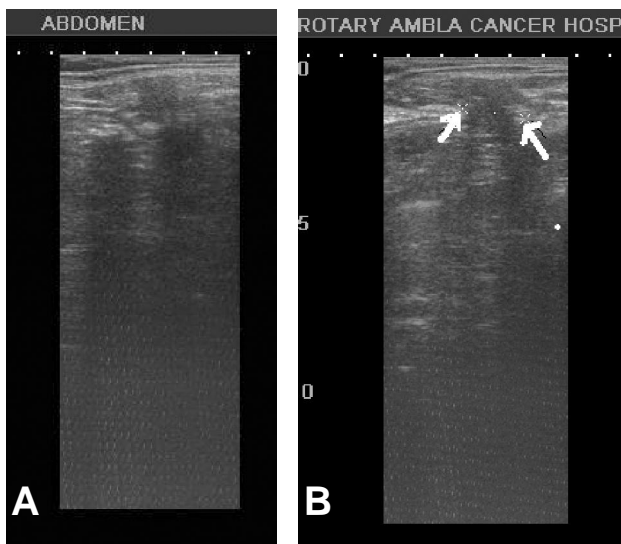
Sagittal sonogram of a left Spigelian hernia. The abdominal wall defect is well identified (White arrows) with herniated omentum in sitting position in figure:1 B.
